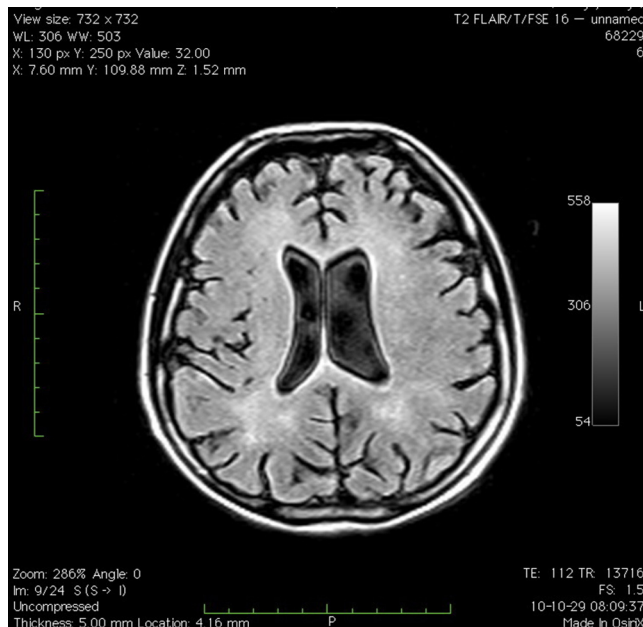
MRI of the brain (FLAIR weighted image), 3 months later: progression of previously described lesions.
